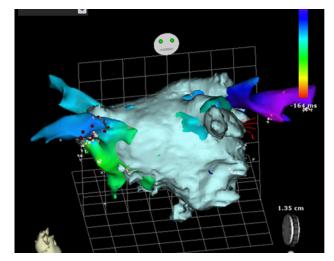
Image integration with the Carto system-Biosense Webster. Excellent fusion between computed tomography of the left atrium and electroanatomical mapping. Anterior view.
